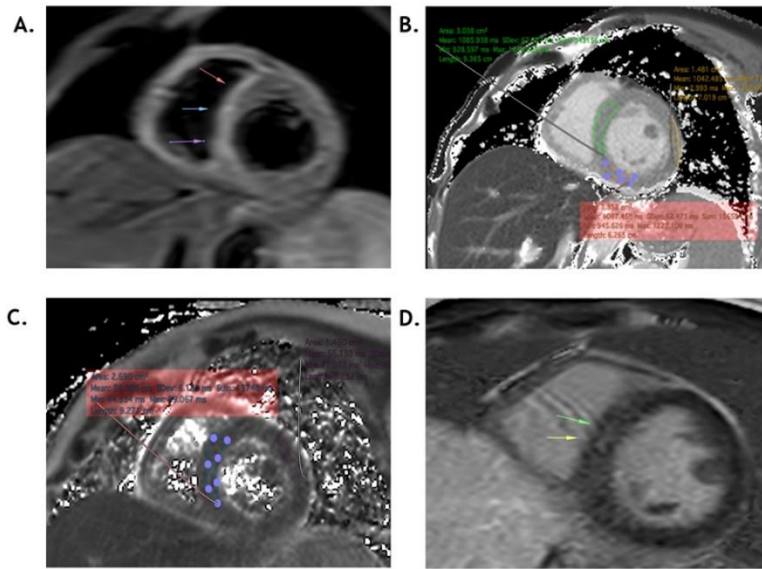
Cardiac magnetic resonance (1.5T). Panel A: T2-weighted sequence showing septal hyperintensity (edema). Panel B: Native T1 mapping with increased relaxation times (1,085 ms) in septal segments. Panel C: Elevated T2 mapping values (59 ms) indicating myocardial edema. Panel D: Early and late gadolinium enhancement demonstrating a non-ischemic subepicardial pattern in basal and mid-septal segments. Findings satisfy modified Lake Louise criteria for acute myocarditis.
